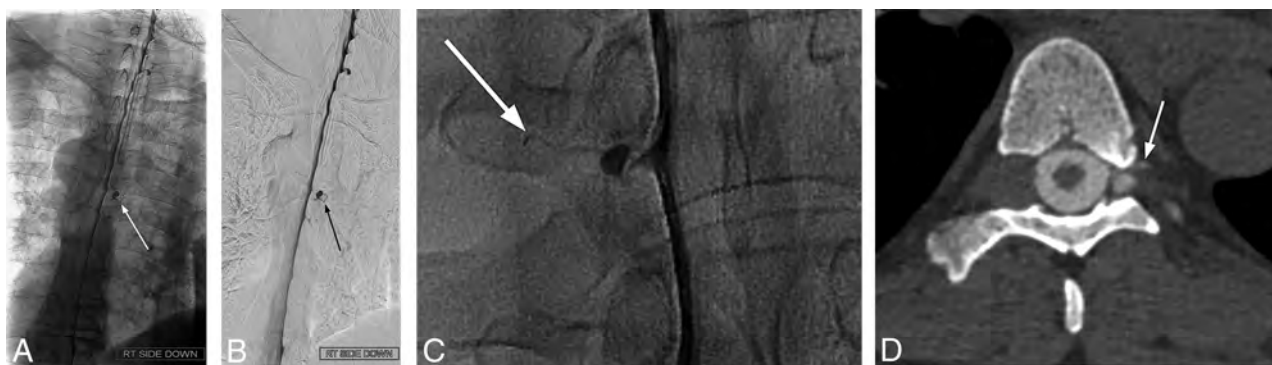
Examples of diagnostic DSM. Full-FOV DSM images from a lower cervical-to-mid-/lower thoracic run clearly delineate a CSF-venous fistula in the unsubtracted image (A) and subtracted image (B). A digitally magnified unsubtracted image from another patient shows a very subtle CSF-venous fistula (C), which is better seen in a subsequent CT myelogram (D).
